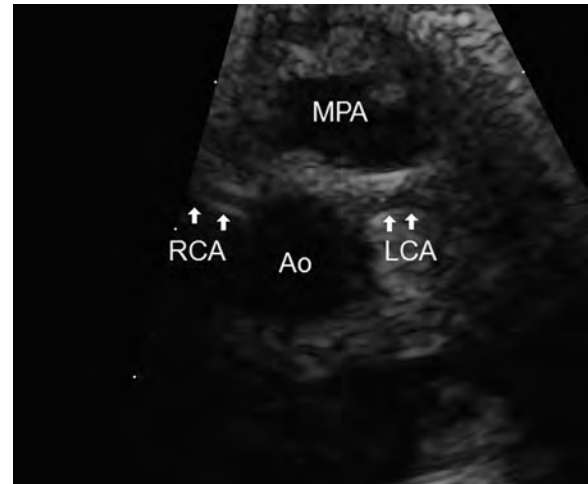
High parasternal view of the CAs in an infant with TGA after the ASO. The proximal course of the right CA (RCA) from the anterior right sinus and the left CA (LCA) from the anterior left sinus of the neo-aortic (Ao) root are visualized. The main pulmonary artery (MPA) is seen anterior to the neo-aortic root.
